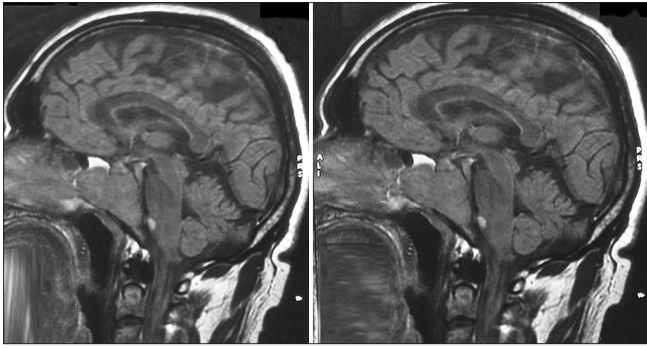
MRI of the brain showing extensive lesion involving the clivus
